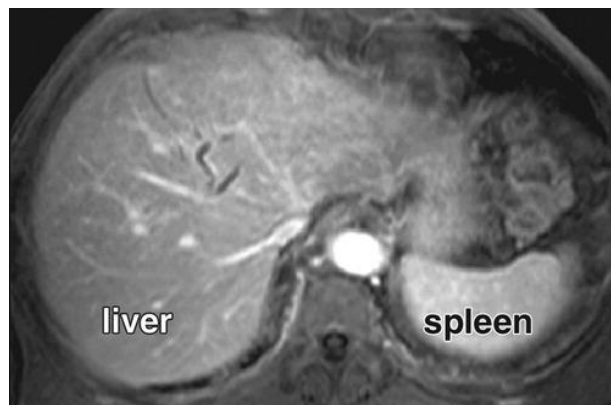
Axial 3D delayed phase GRE T1-weighted image obtained 2–5 minutes after contrast material injection shows no pathologic findings. This sequence is essential for the further characterization of liver lesions detected during the arterial phase. (16)
